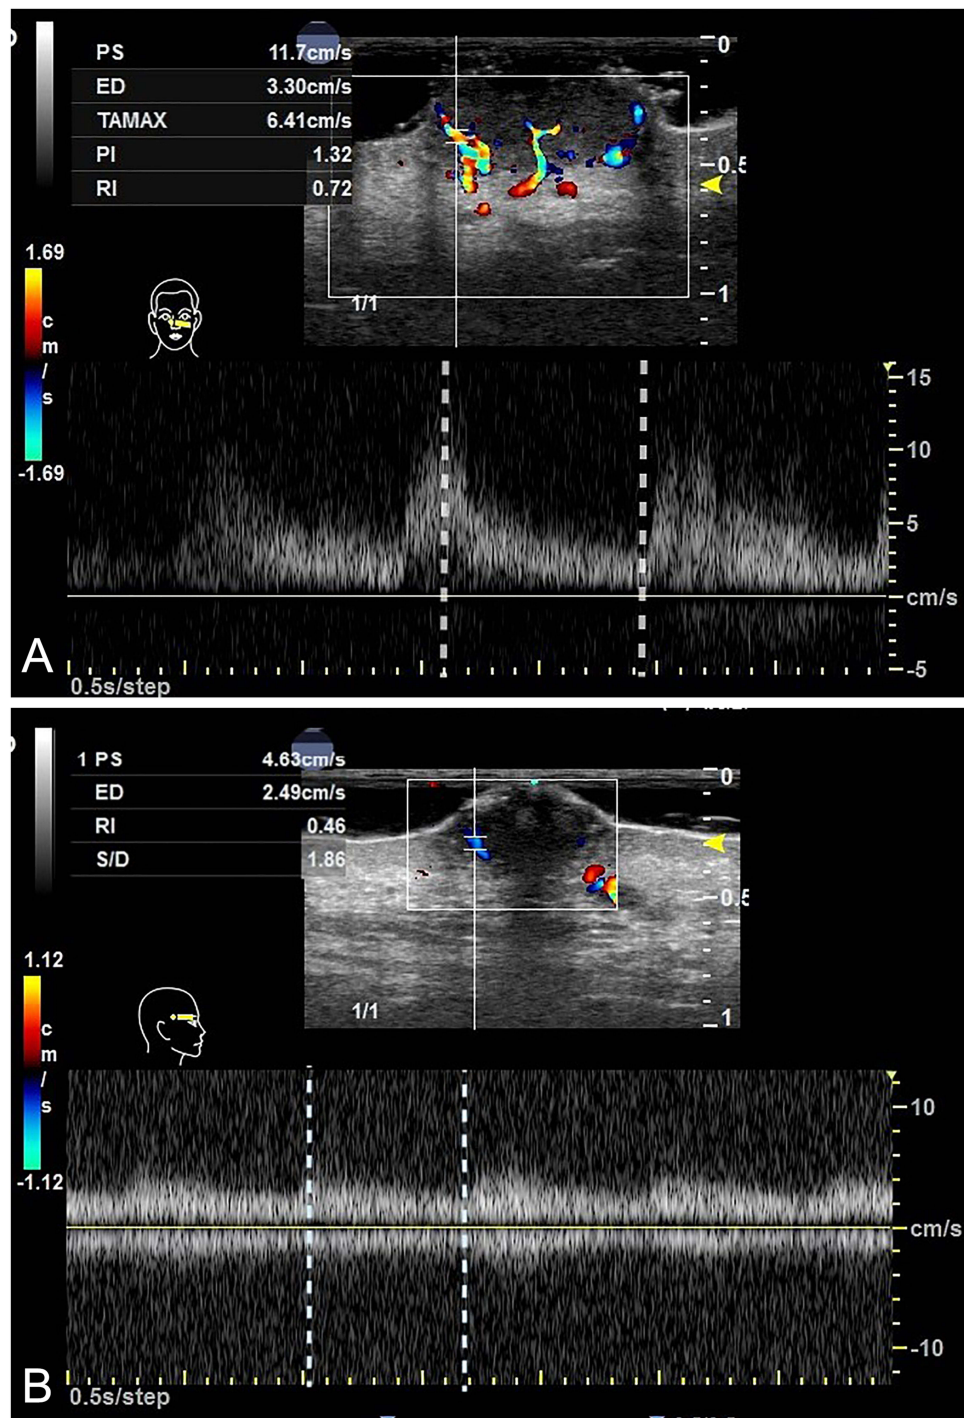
(A) Malignant pigmented skin lesion (basal cell carcinoma): Spectral Doppler shows high-resistance blood flow, with a resistance index (RI) of 0.72. (B) Benign pigmented skin lesion (keratoacanthoma): Spectral Doppler shows low-resistance blood flow, with a resistance index (RI) of 0.46.
